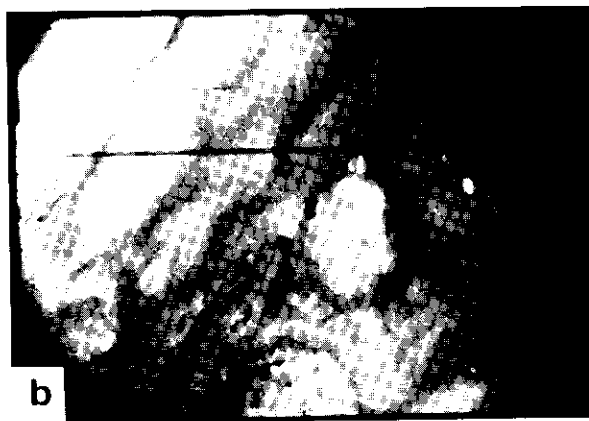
X-ray (a) and endoscopic (b) appearance of gastric polyps of case P-J 23, III-3.
